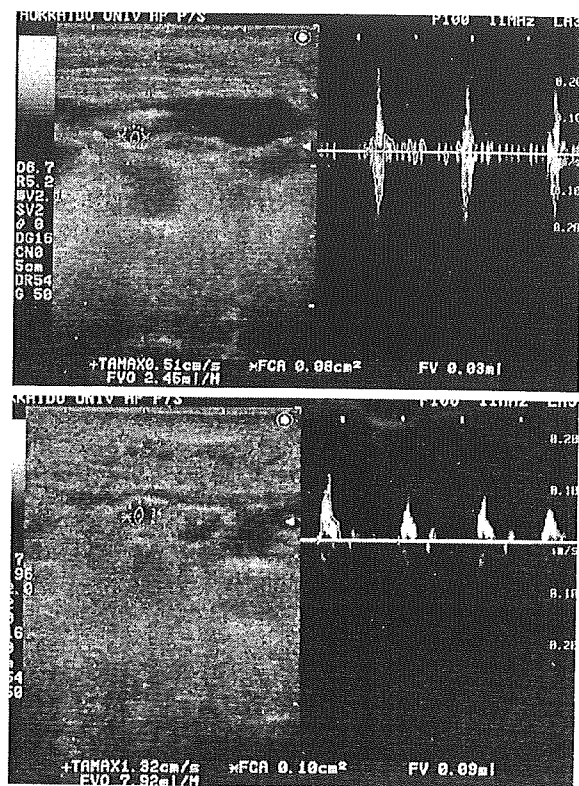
Changes in Doppler arterial waveforms before and after venous reanastomosis in a patient with venous thrombosis. (Above) Before venous reanastomosis, the arterial waveform indicated turbulence, with systolic antegrade and diastolic retrograde flows. Flow volume output was 2.45 ml/minute. (Below) After venous reanastomosis, the arterial waveform was improved and the flow volume output increased to 7.92 ml/minute.
